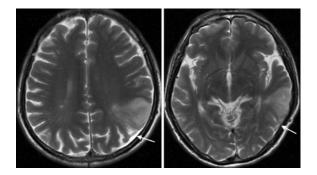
T_2 -weighted MRI showing an infarction in the left parietotemporal region.
